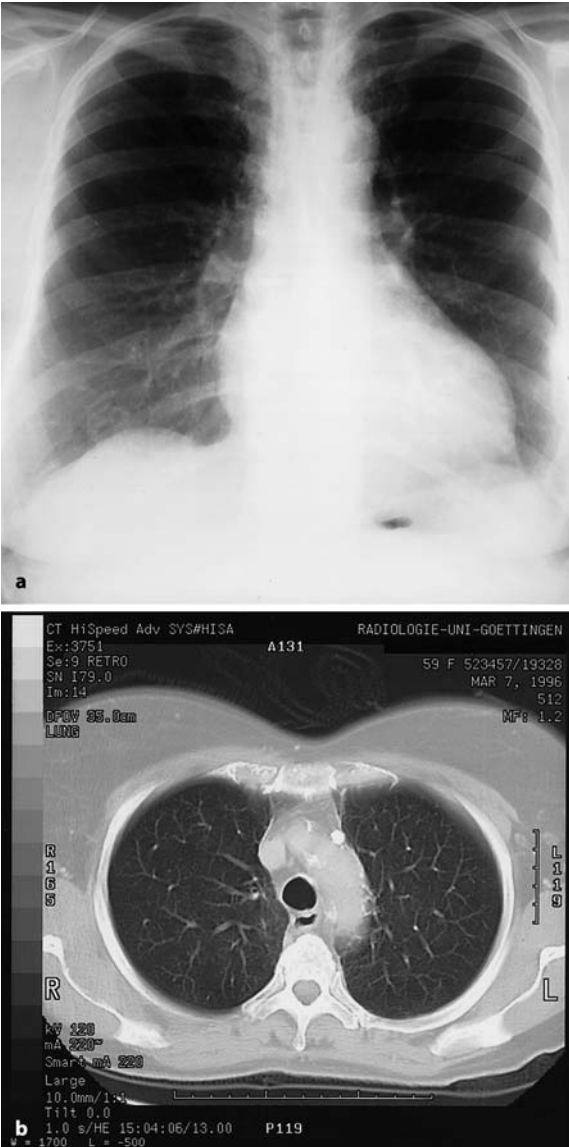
a-d Metastatic involvement of mediastinal lymph nodes in a woman with occult metastatic MTC. Whereas the chest radiograph (a) is without pathological findings and a CT scan of the chest (b) merely shows some nonspecific calcified lymph nodes, somatostatin receptor scintigraphy (c) shows typical bilateral lymph node involvement (“chimney sign”). By contrast, FDG-PET (d) is false-negative
